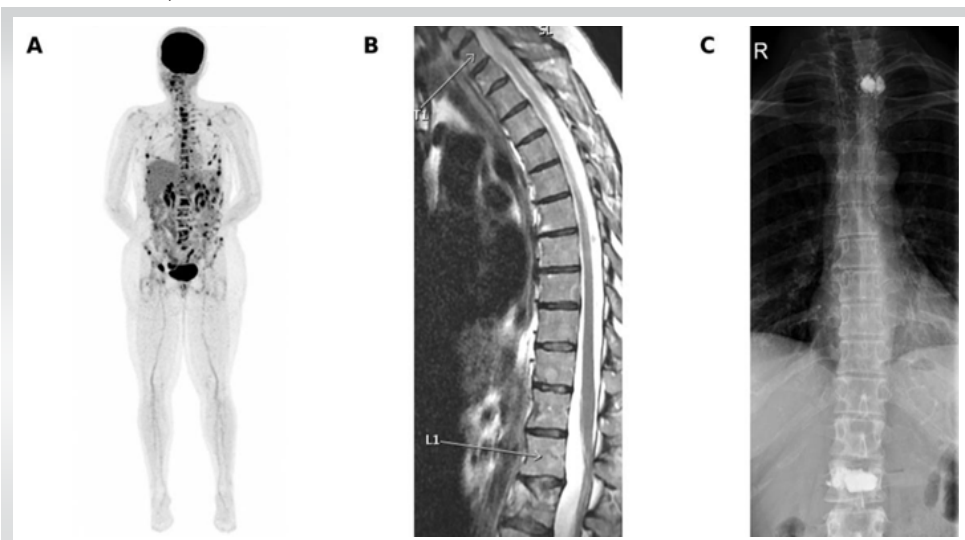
Oncologic spine imaging at presentation. (a) Whole-body positron emission tomography-computed tomography maximum-intensity projection showing multifocal hypermetabolic osteolytic lesions across the axial skeleton. (b) Sagittal thoracolumbar magnetic resonance imaging showing metastatic vertebral involvement. (c) Anteroposterior thoracolumbar radiograph after previous vertebral augmentation.
